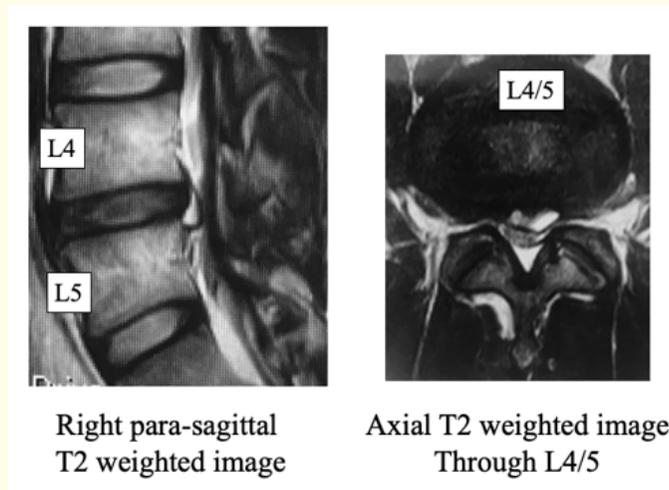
Magnetic resonance images obtained before surgery. The herniated nucleus pulposus has a very high signal intensity, suggesting a discal cyst.
